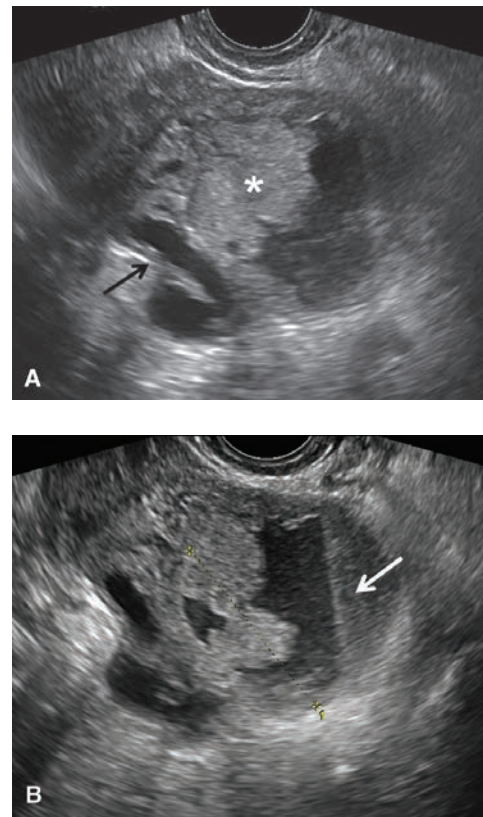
A 52-year-old woman with fallopian tube carcinoma initially diagnosed as tubo-ovarian abscess. She presented to the emergency department with left lower quadrant pain, and fever. A: Transvaginal ultrasound demonstrates a complex left adnexal mass with a tubular in configuration fluid-filled component (arrow) and a solid component (*). B: Additional image demonstrates a fluid-debris level within this mass (arrow). Initially, this was thought to represent a tubo-ovarian abscess; however, the patient had no risk factors for pelvic inflammatory disease. At surgery, fallopian tube carcinoma was found.
